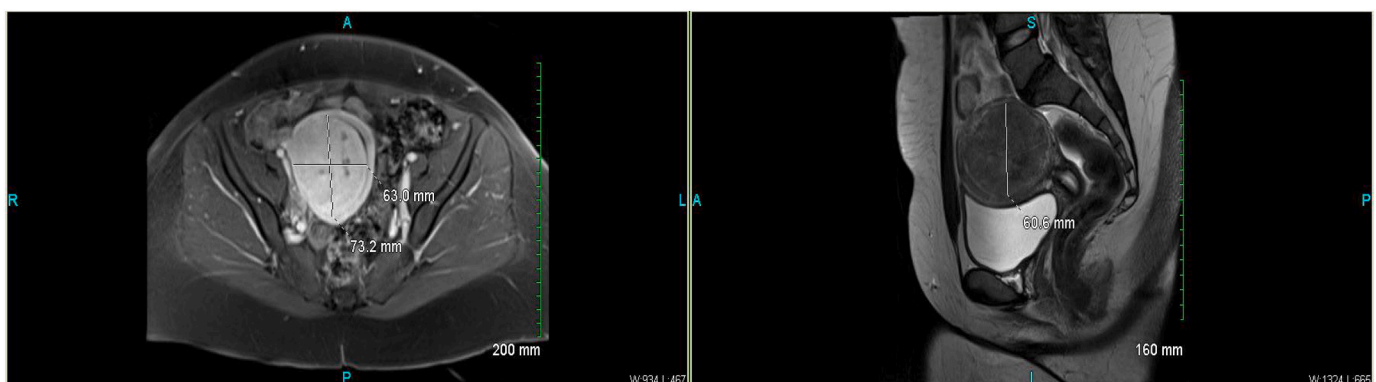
MRI of the uterine inflammatory myofibroblastic tumor.
